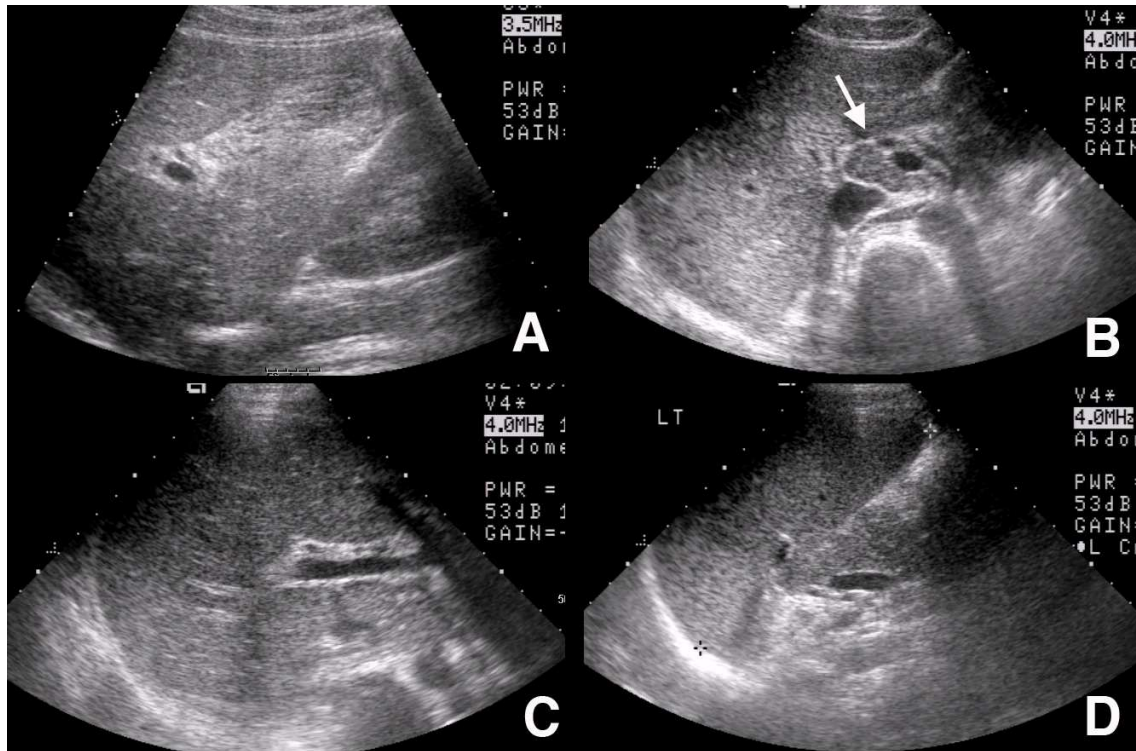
Abdominal ultrasonography of a 13-year-old female with infectious mononucleosis. A. Gallbladder shows diffuse mural thickening. B. Lymphadenopathy is note at porta hepatis. C. Liver shows increased periportal echogeneity. D. Spleen is enlarged.
